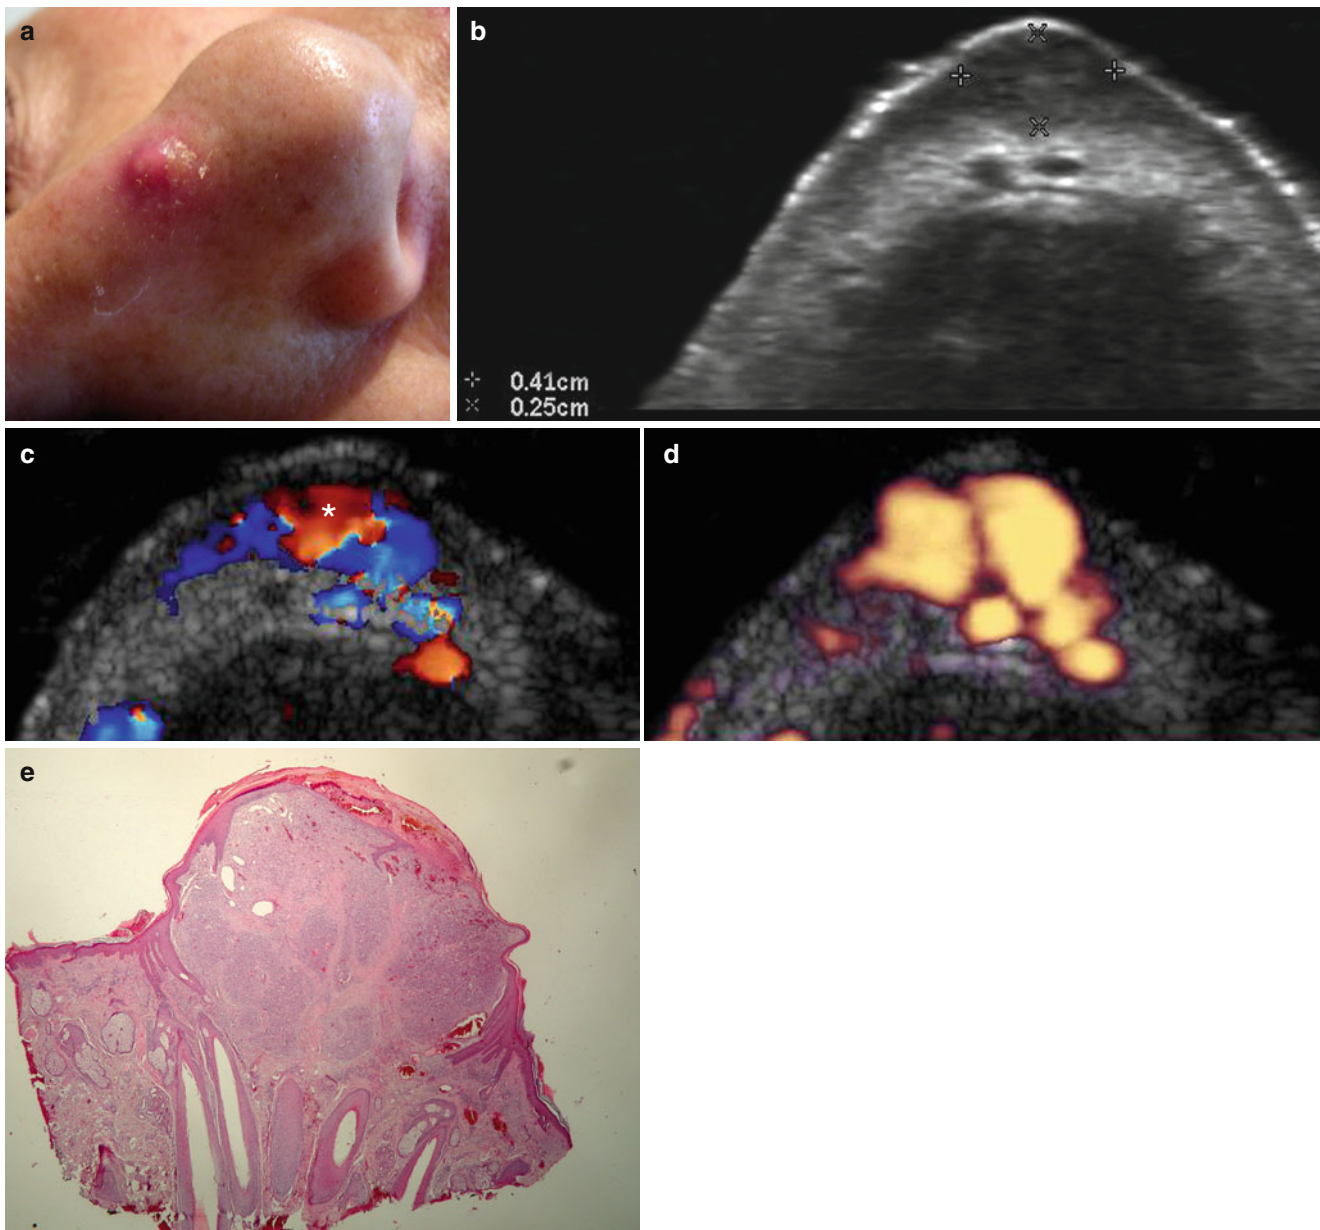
(a–e) Pyogenic Granuloma. (a) Clinical image shows erythematous swelling in the dorsum of the nose. (b) Grey scale ultrasound (transverse view): 0.41 × 0.25 cm hypoechoic nodule that affects dermis and upper subcutaneous tissue. (c) Color Doppler ultrasound and (d)
